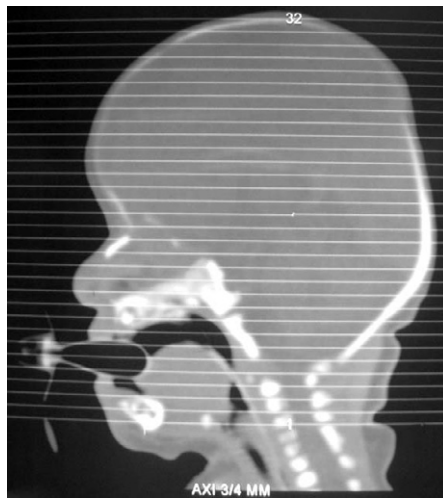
Sagittal computed tomography scan of the skull showing brachycephaly, midface hypoplasia, a narrow and retruded maxilla, a high-arched palate, and a decreased nasopharyngeal airway.
